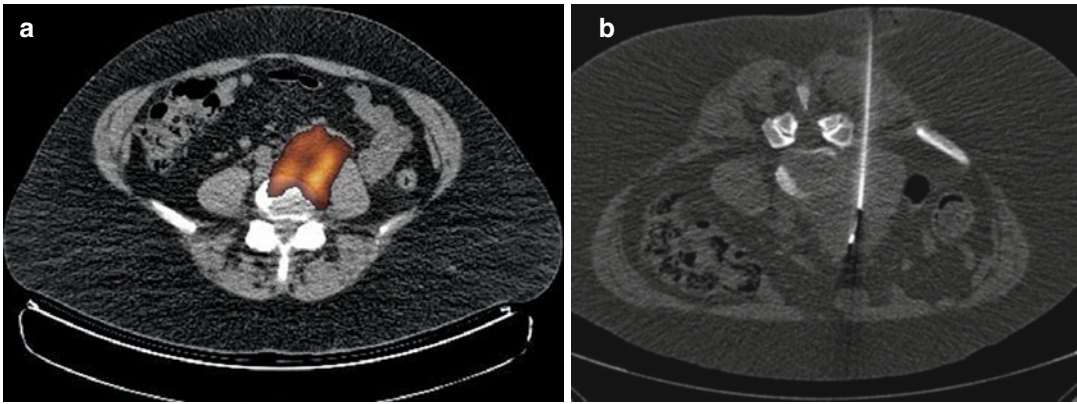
(a, b) Percutaneous lymph node biopsy. (a) Axial PET/CT fusion image demonstrating active nodal disease adjacent/enveloping left common iliac artery due
